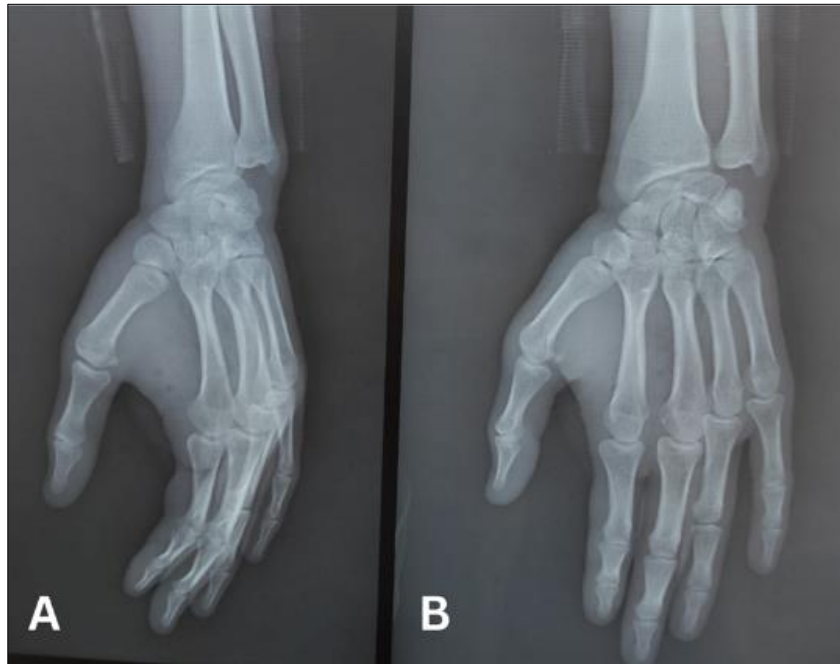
(A+B) Radiograph 6 months postoperatively
